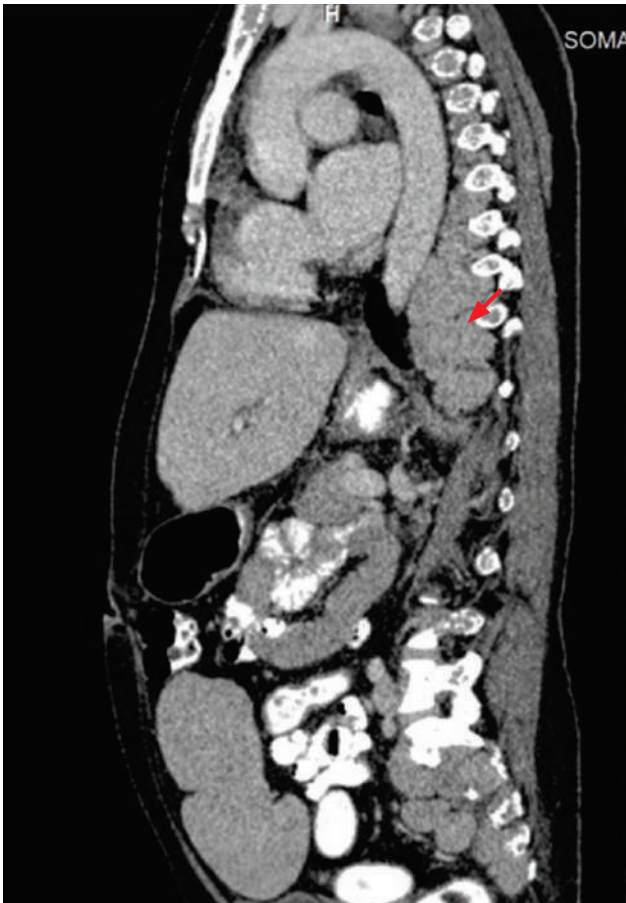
CT scan of thorax, abdomen, pelvis in 2018 (sagittal view) showing paraspinal mass (red arrow).
